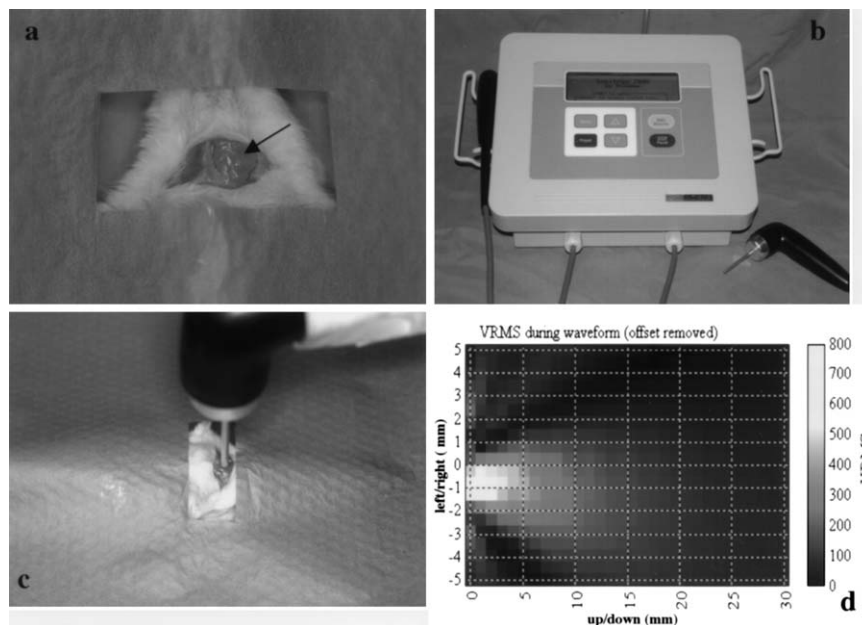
(a) A bilateral submandibular incision was made to create an acoustic window for LIFU application. (b) Sonitron 2000 with probes (ultrasound device from Rich-mar Corp.). (c) Set-up for the *in vivo* experiments. The LIFU probe is mounted on the positioner and the tip of the probe gently touches the surface of the submandibular gland. Ultrasound transmission gel was used to couple the probe tip to the surface. (d) Characterization of the acoustic field. Peak positive pressure field generated by ultrasound at 1 MHz 3 W/cm<sup>2</sup> with a duty cycle of 100% with a 3-mm probe, as measured in water. The origin of the acoustic beam is at the left edge of the beam plot and its focal length was 3.5 to 4.0 mm from the tip of probe. The scale at the right of the beam plot gives LIFU power as a function of color: black = minimum; white = maximum.
